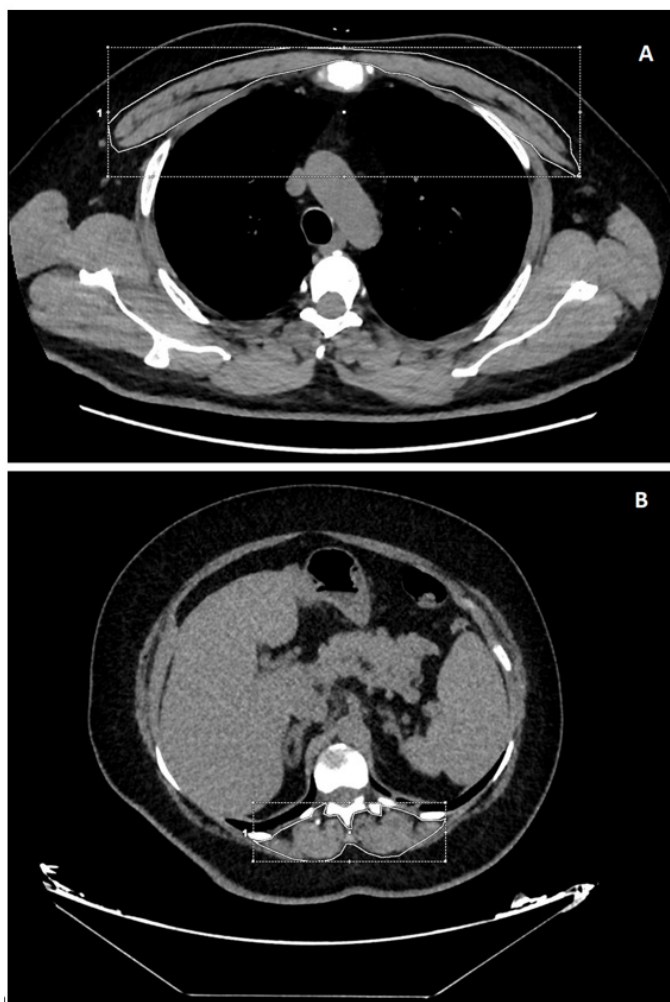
A: Region of interest (ROI) was circumscribed manually by two different radiologists for obtain PMA and PMD at the upper half level of T4 vertebra. B: PSMA and PSMD at the lower half level of T12 vertebra.
